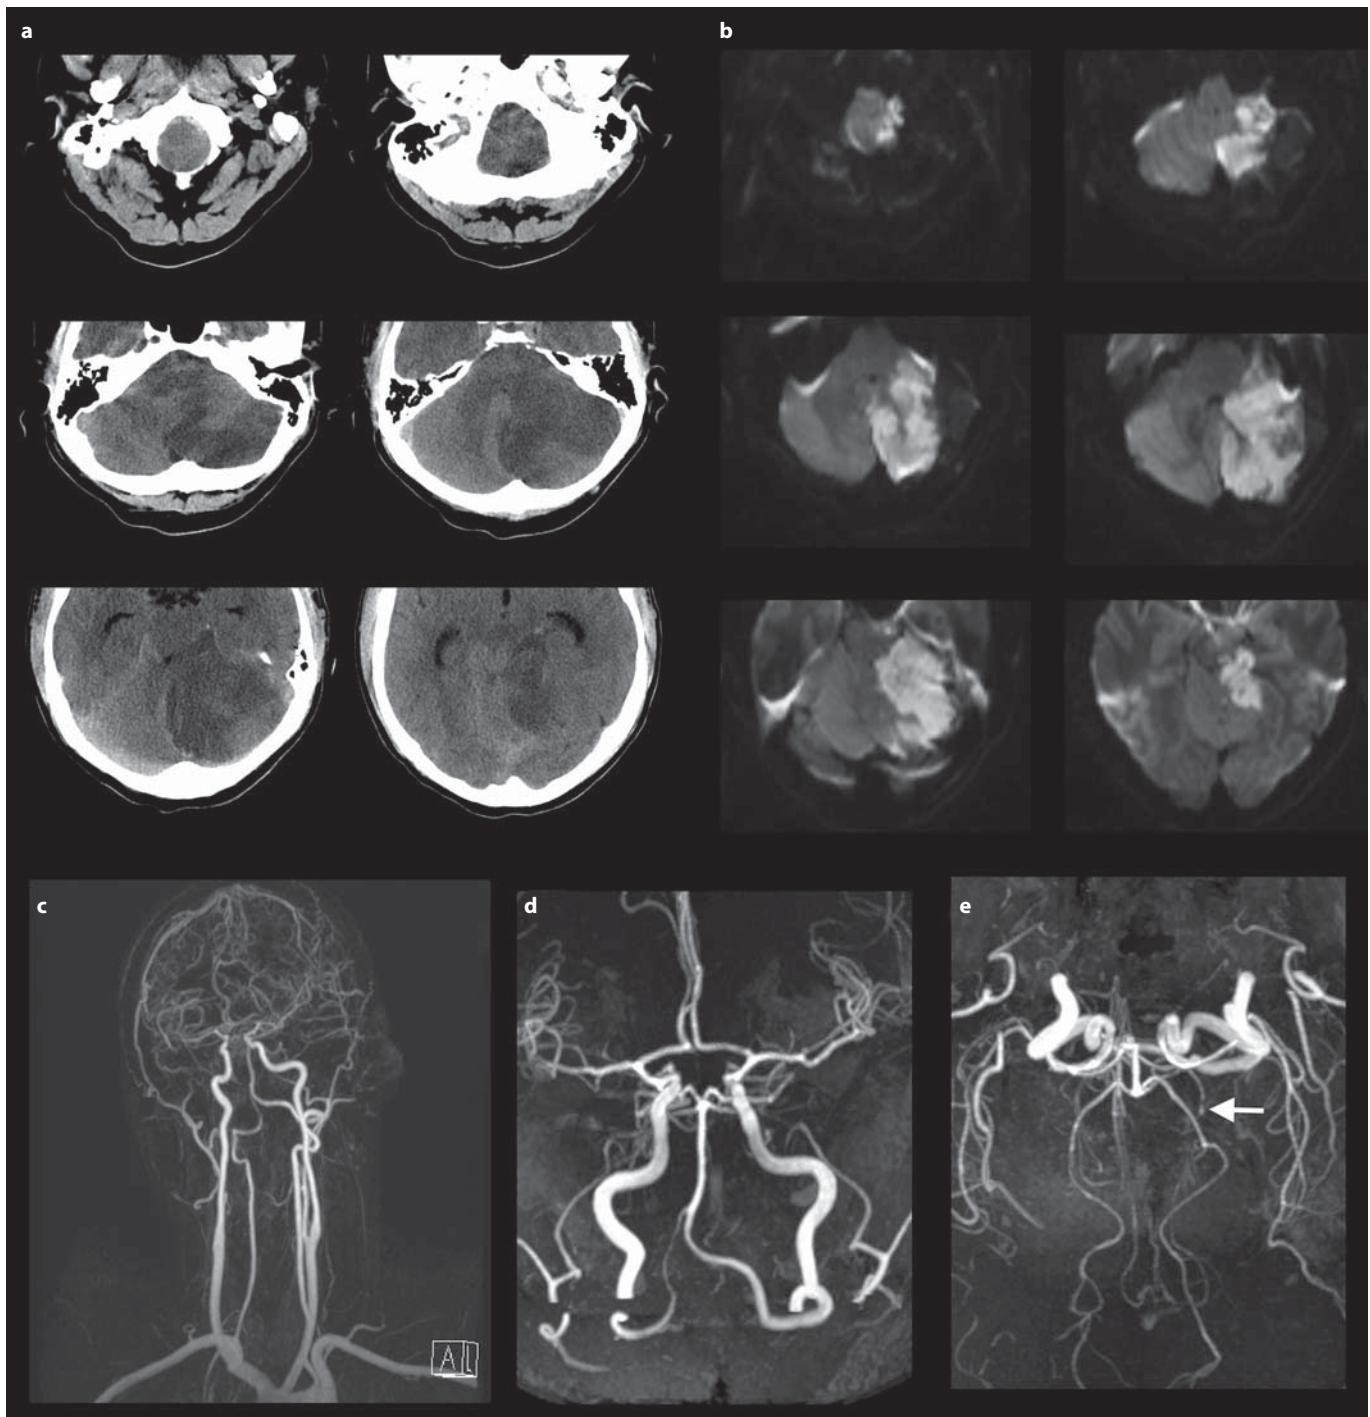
a, b Horizontal sections demonstrating a large infarction within the left cerebellar hemisphere (a CT, b DWI-MRI) and left pontine and posterior mesencephalon (DWI-MRI). c–e Angio-MRI. c Cervical fast imaging with steady-state precession with gadolinium bolus showing the normal VAs. Note the hypoplastic aspect of the RVA. d, e Intracranial time-of-flight angiography. Note the absence of AICA and PICA bilaterally, and the stop on distal left SCA (e, white arrow).
